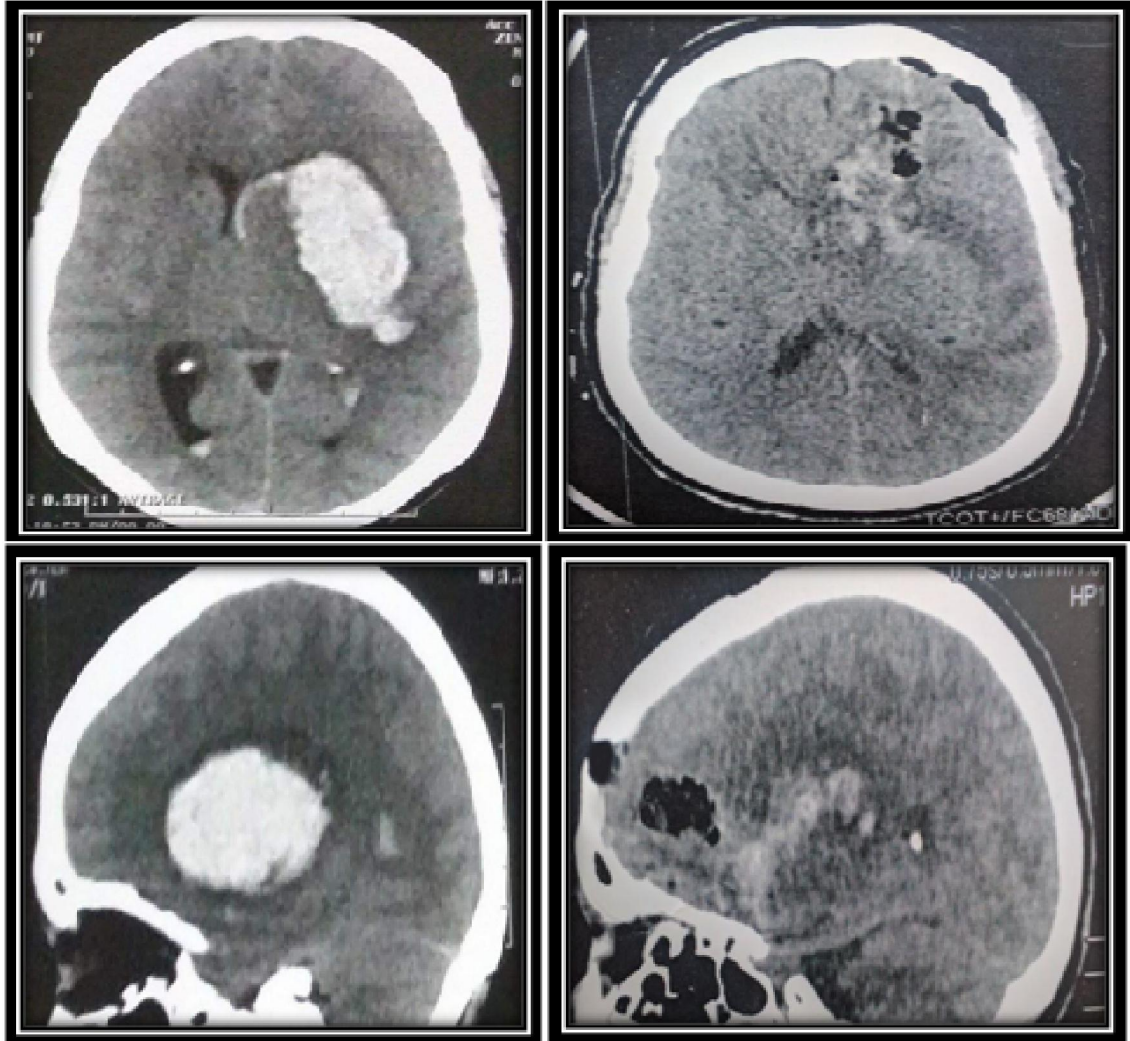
showing comparison between preoperative CT brain (axial, sagittal) of a female 45y. patient has left 35cc hematoma with GCS 8 and postoperative CT brain (axial, sagittal) of the same patient with surgical entry point at long. axis of hematoma (Frontal burr hole). Evacuation rate was 97 %.
